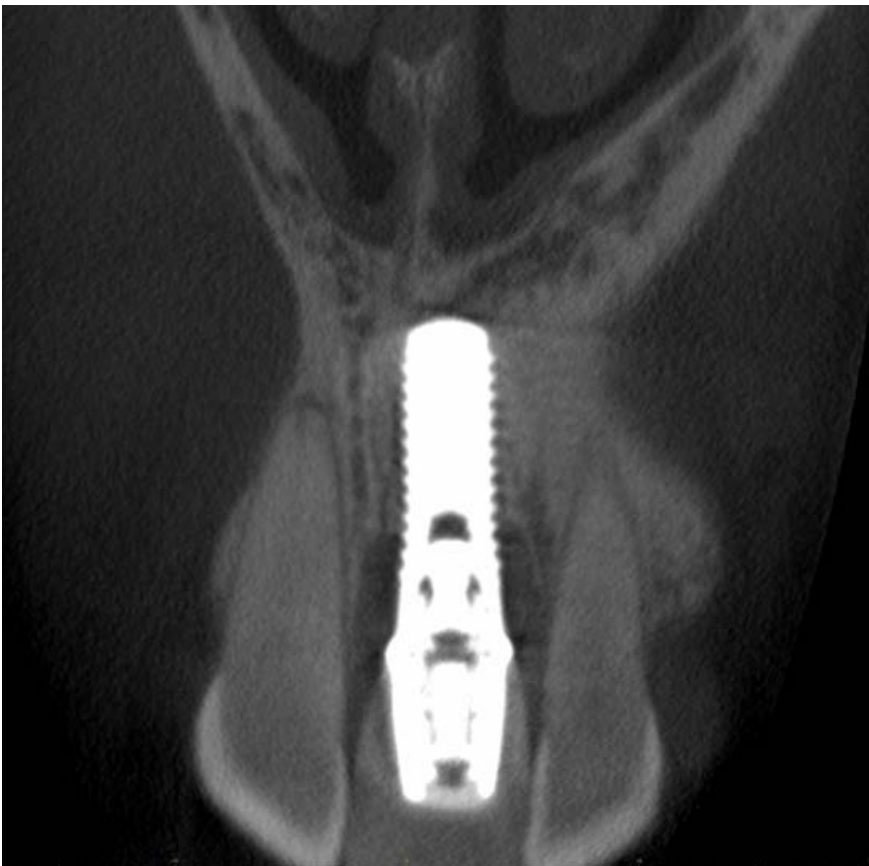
Sagittal CBCT slice
